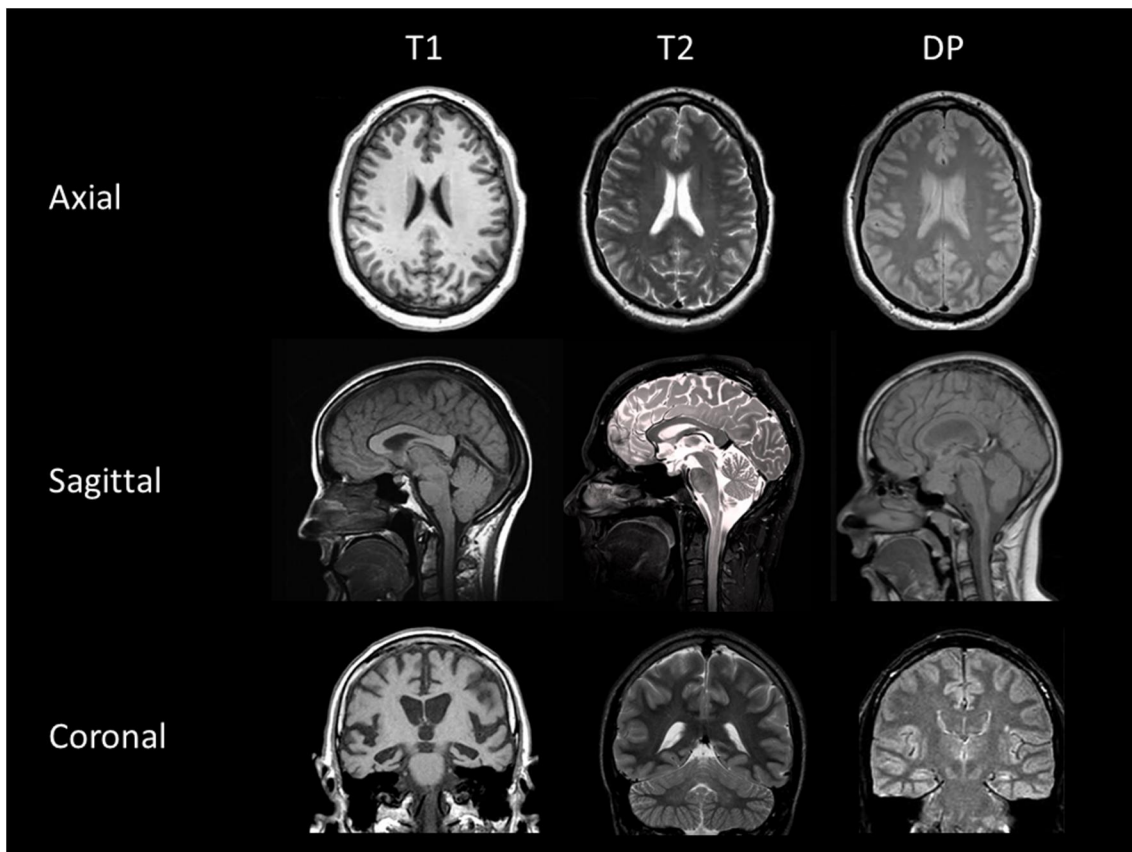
Brain MRI images. In this figure, the three different basic contrasts of brain MR images can be observed: T1-, T2-, and proton density-weighted images. The images are organized to show the difference in contrast between the three anatomical planes: axial, sagittal, and coronal.
